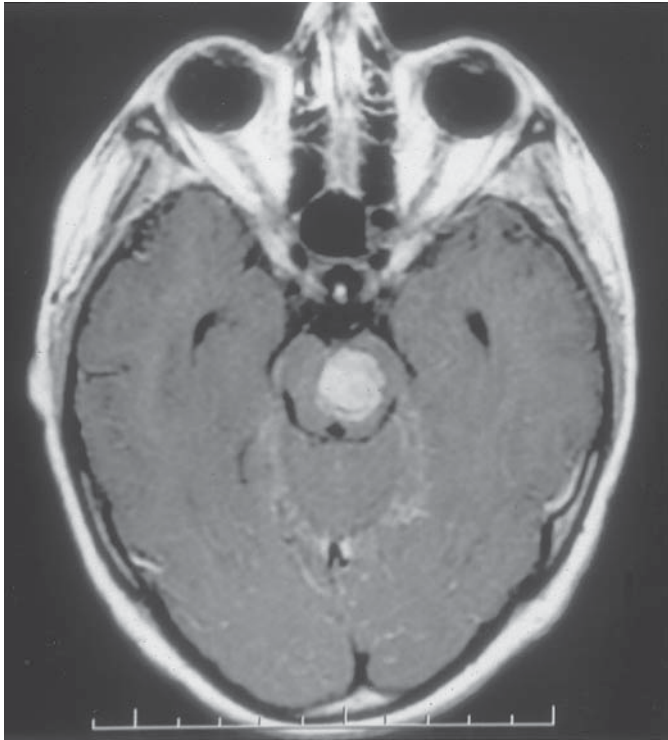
MRI of the brain showing a hemorrhagic metastasis from choriocarcinoma in the mesencephalic region (T1 weighted image after gadolinium injection).
